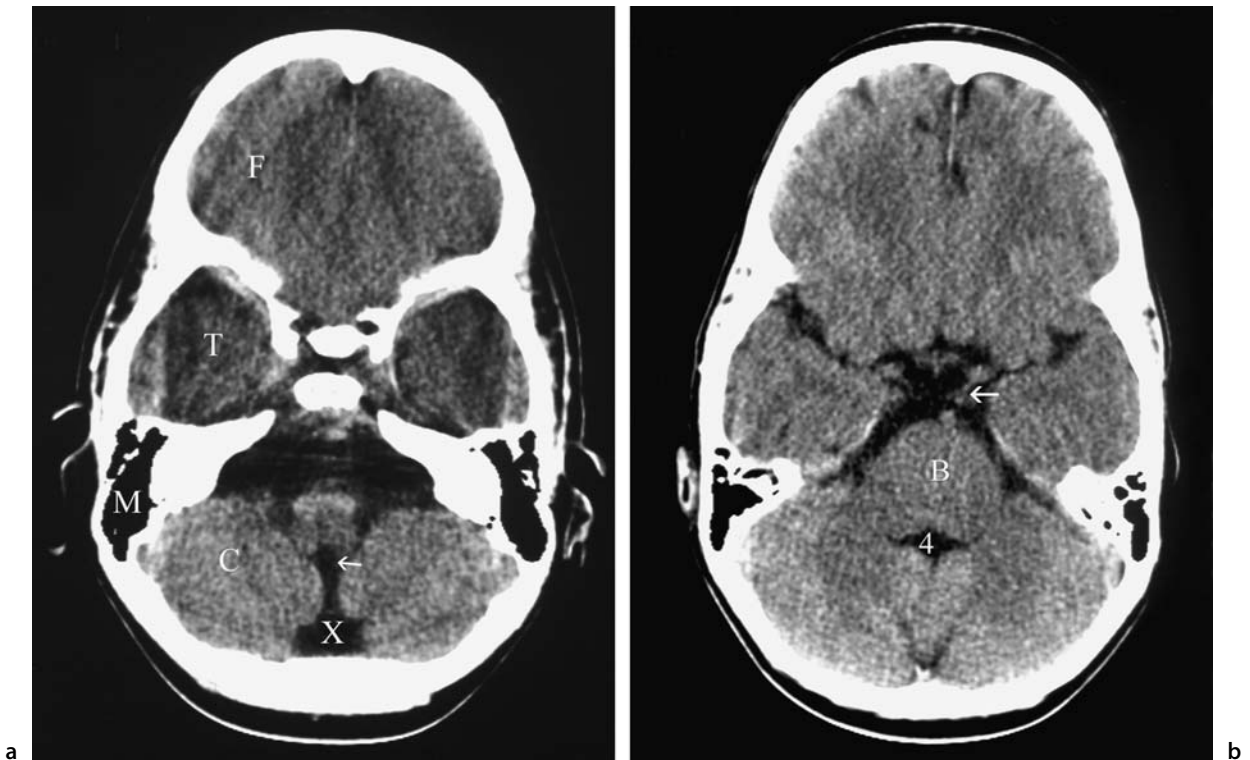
Normal CT scan of the brain.
